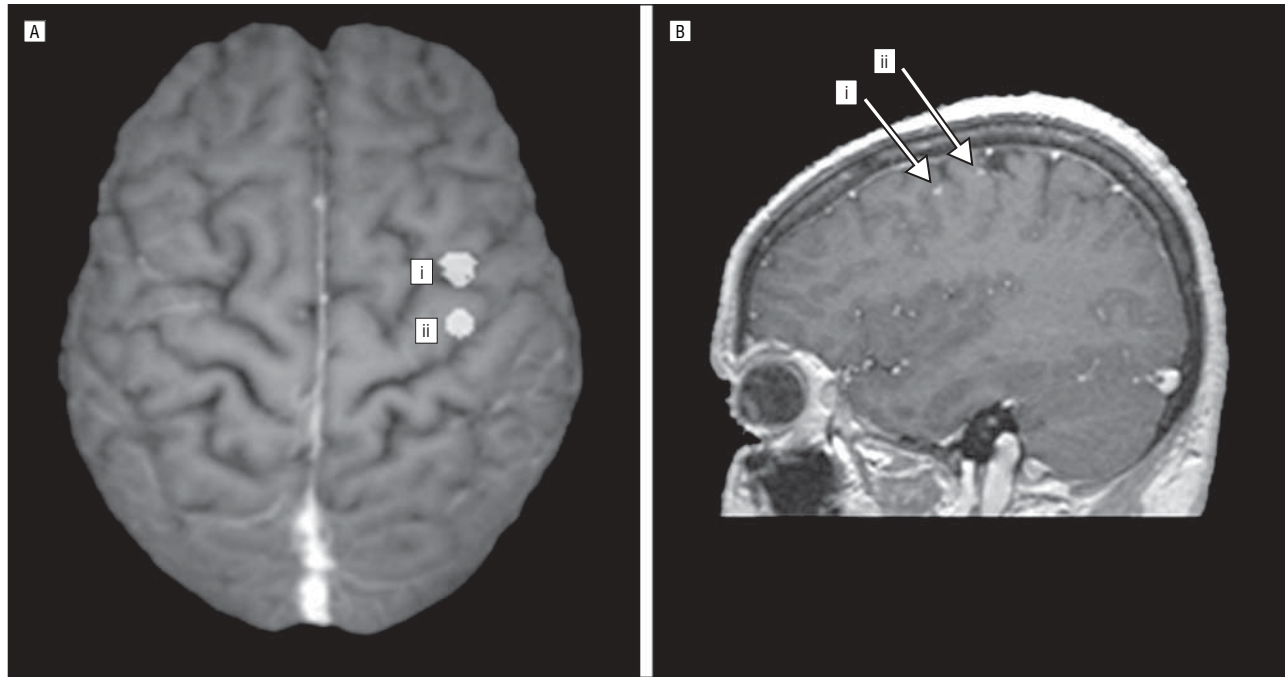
Lesion location. A, Three-dimensional reconstruction of a T1-weighted magnetic resonance image. The 2 small lesions confined to the right premotor cortex (i) and motor cortex (ii) are projected on the cortical surface. B, Magnetic resonance image (T1-weighted, with gadolinium enhancement; sagittal section) showing the 2 hypointense small ischemic lesions.
